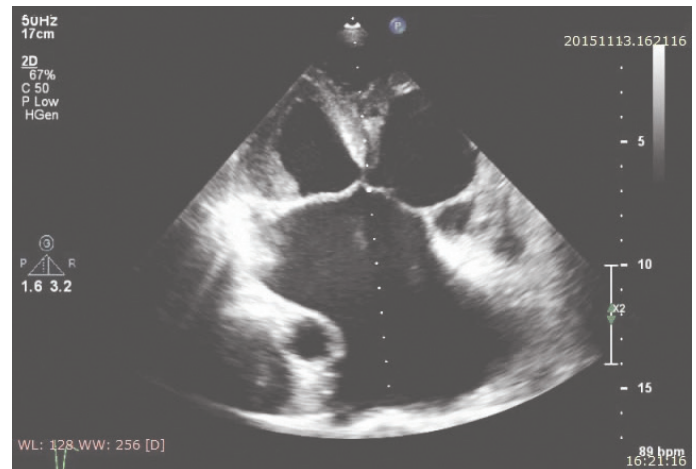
Two-dimensional apical four-chamber image of single atrium
